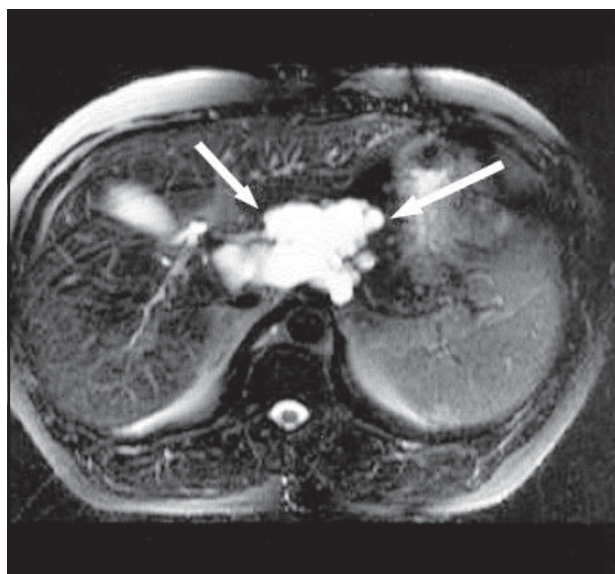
T2-weighted magnetic resonance image shows hyperintense signal of the lesion.
